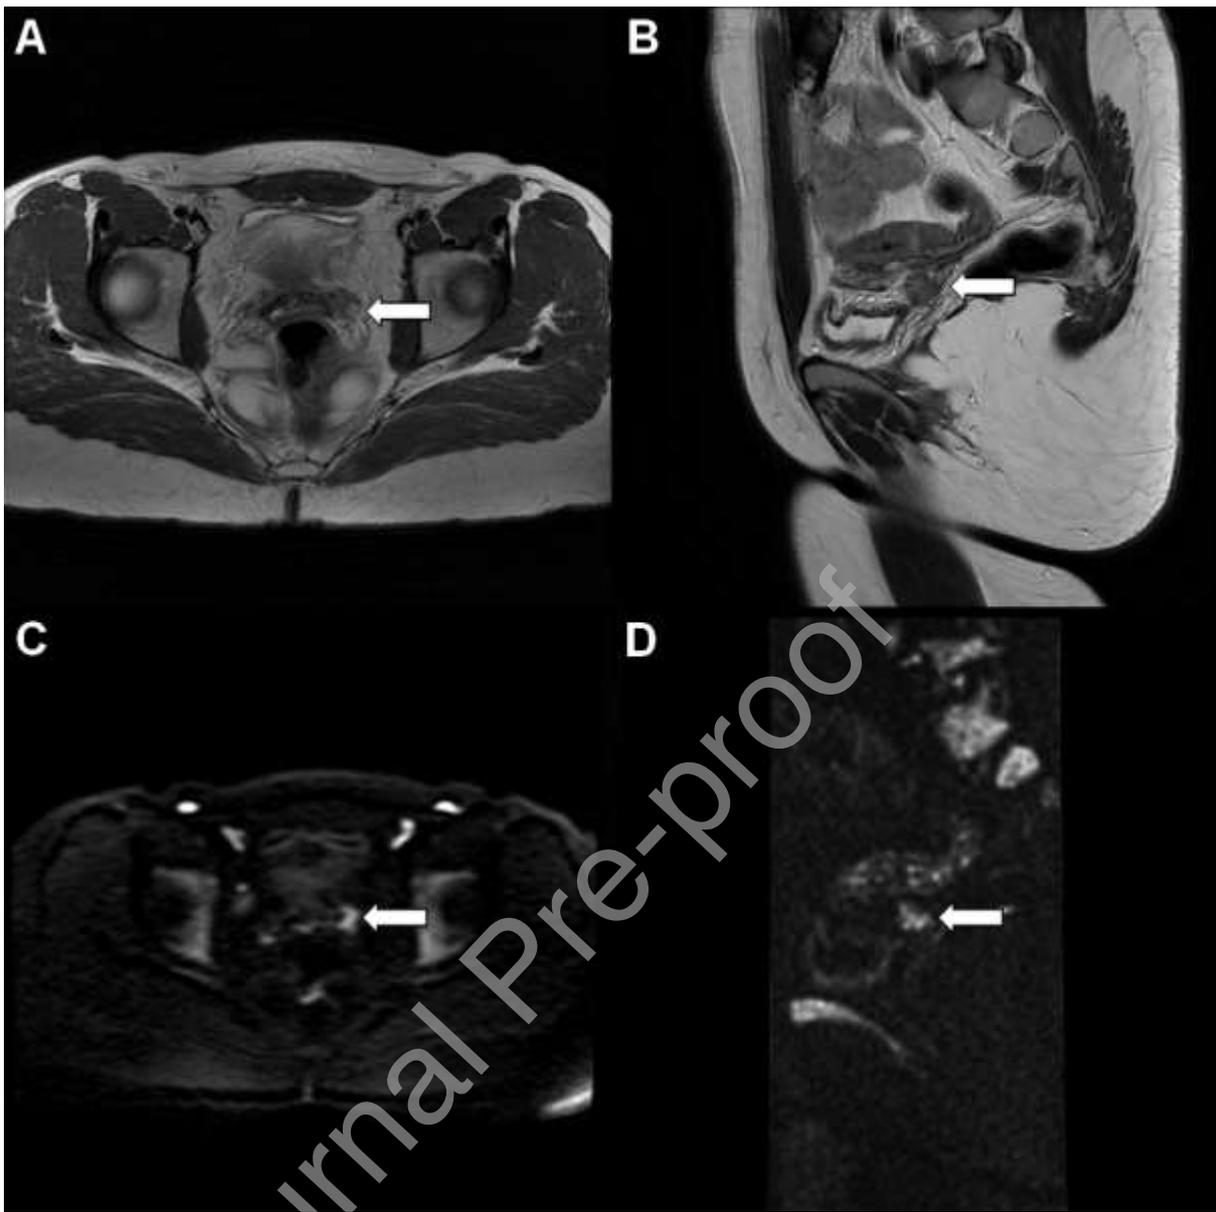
Axial and sagittal T2 (A, B) and diffusion (C, D) magnetic resonance imaging slices showing the left parametrial recurrence (white arrow).
